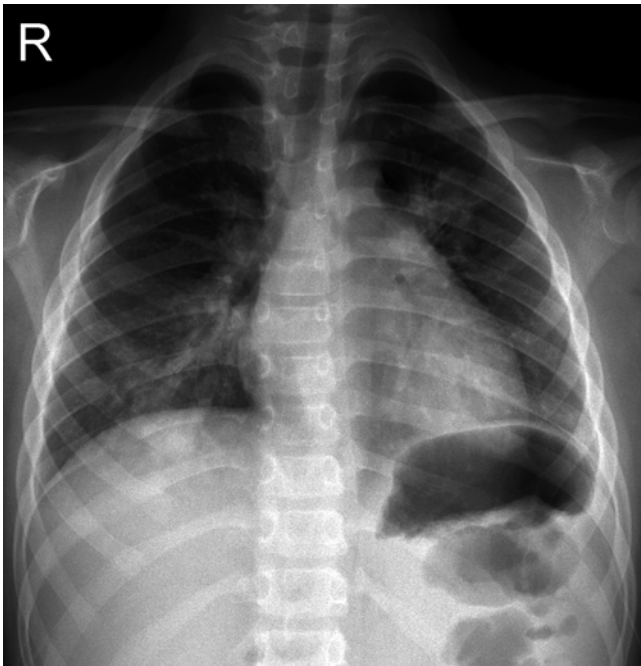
AH1N1 virus pneumonia. Frontal chest radiograph shows generalized increase interstitial markings with multifocal patchy infiltrates (Case courtesy of Xanthe Marie Javier MD, from Philippines)
